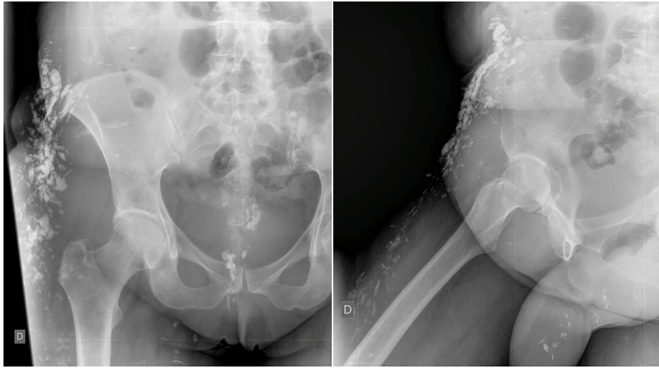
Anteroposterior and oblique radiograph of the inguinal region presenting with calcinosis cutis in the direct inguinal region, flanks, and perianal region.
